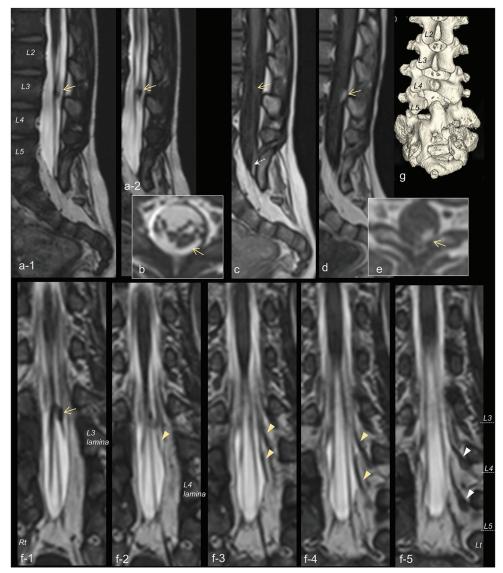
Sagittal (a-1 and 2) and axial (b) views of three-dimensional heavily T2-weighted imaging (3D-hT2WI) demonstrating a tumor (yellow arrow) in the cauda equina. (c) 3D T1-weighted images (3D-T1WI) showing the isointense lesion (yellow arrow) of the cauda equina and a high intensity lesion (dotted arrow) of the terminal filum. Sagittal (d) and axial (e) views of 3D-T1WI demonstrating the tumor enhanced with gadolinium (yellow arrow). (f-1-5) Serial coronal views of 3D-hT2WI delineating that the tumor (yellow arrow) is located in the dorsal nerve roots (yellow arrowheads) that enter the dural sac at the left L3-L4 and L4-L5 intervertebral space. Normallypositioned dorsal root ganglions (white arrowheads) are observed at the root sleeves as local bulging. The level of each vertebral body is indicated by a dashed line. (g) 3D reconstructions of computed tomography image revealing spina bifida below S2 and abnormal fusion of the sacral lamina of L5-S2.
